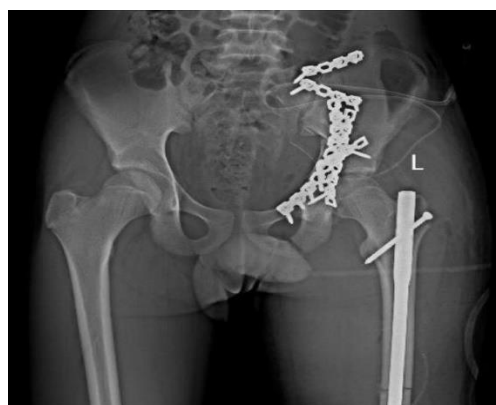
Postoperative anteroposterior (AP) radiograph of the pelvis
